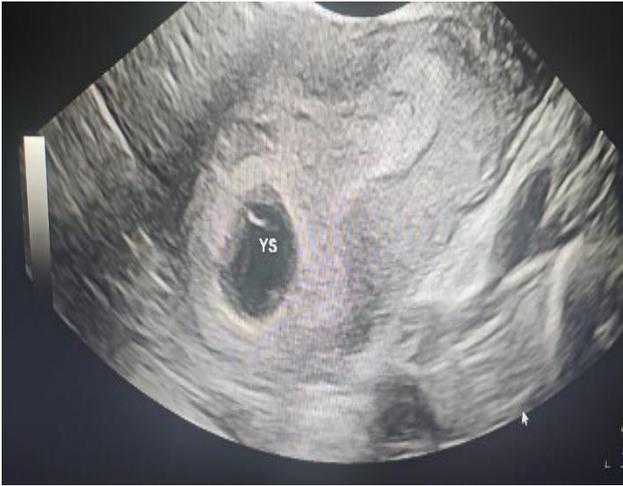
Ultrasound image suggesting an early intrauterine pregnancy.
